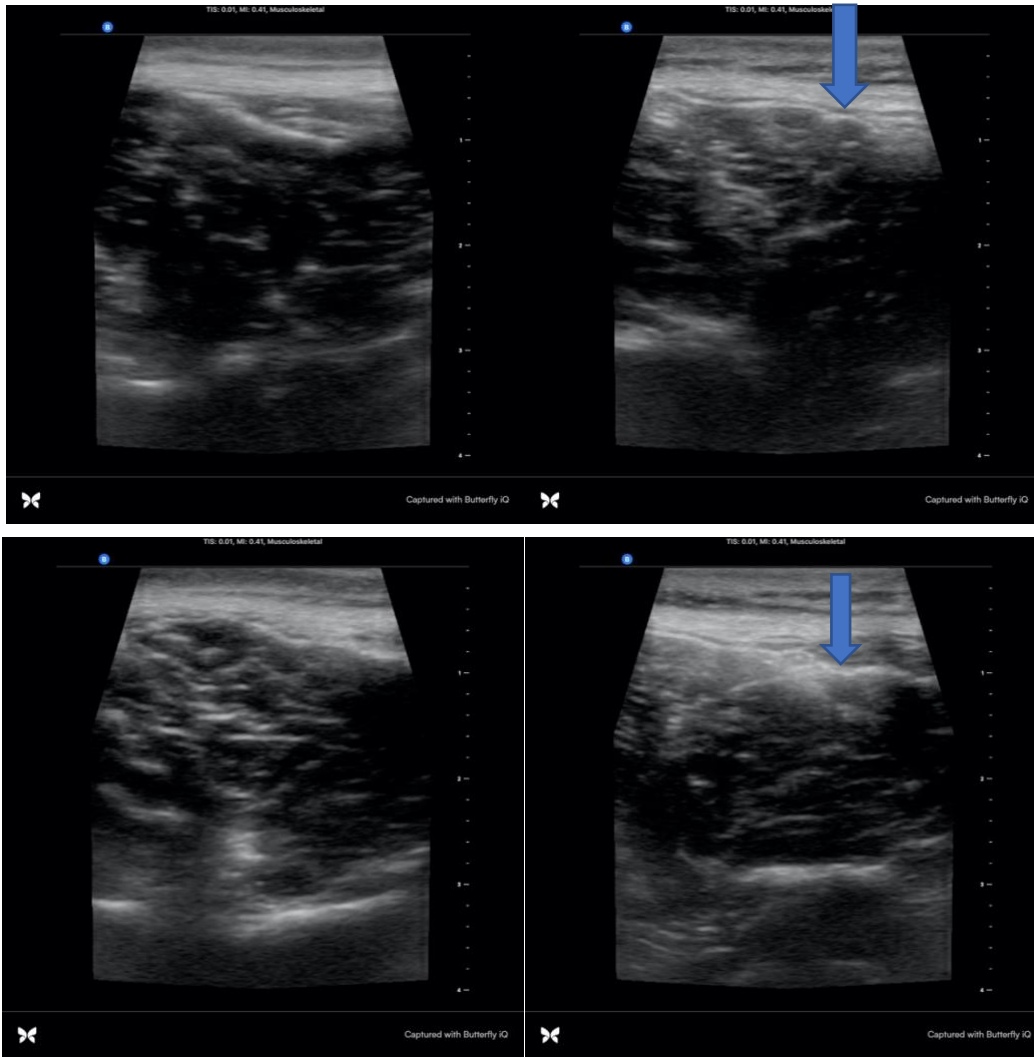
A qualitative comparison of screen captured ultrasound images taken with a ButterflyIQ ultrasound. Both sets of images were taken with two different operators. Left: visualization of the PSM without the belt. Right: visualization with the use of a guiding belt. Qualitative comparison of the two groups demonstrates more consistent reflectance patterns across multiple operators with the aid of a guiding belt. Blue arrows indicate the consistent border of the PSM in images taken with the belt. These borders were not able to be visualized in images taken without the belt.
